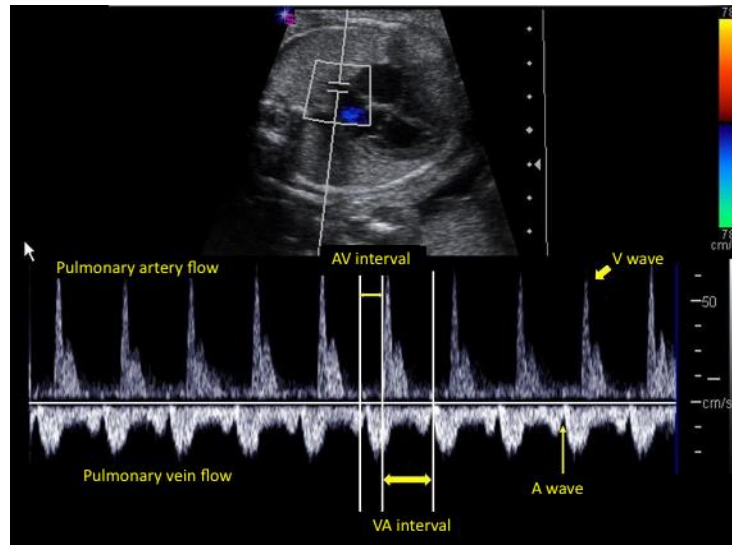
Pulmonary artery-vein pulsed Doppler. In the upper part of the tracing, the pulmonary artery V waves are identified, and in the lower part, the pulmonary vein A waves.
